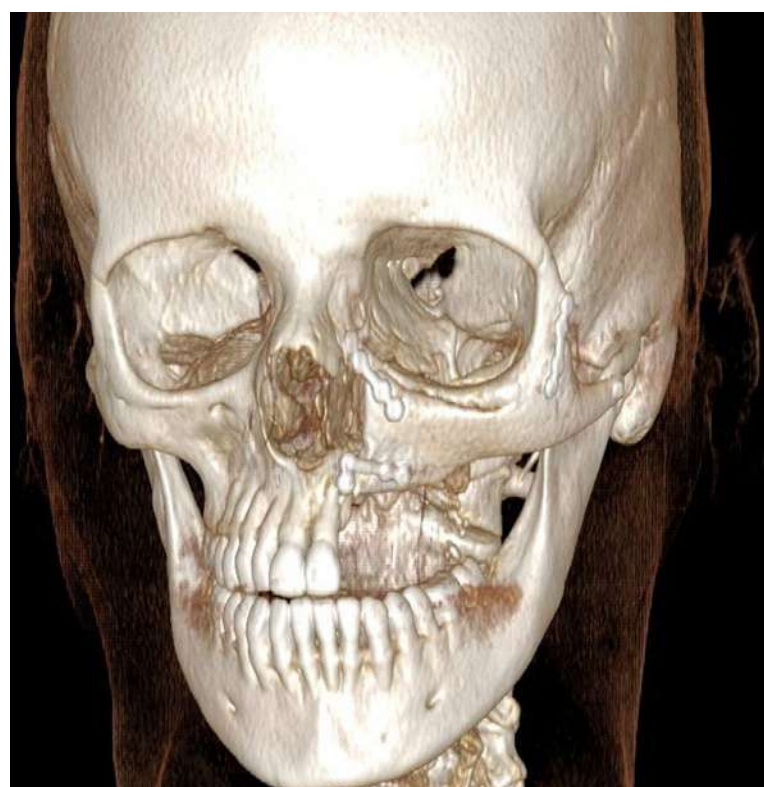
Control CT scan at 14 months.
